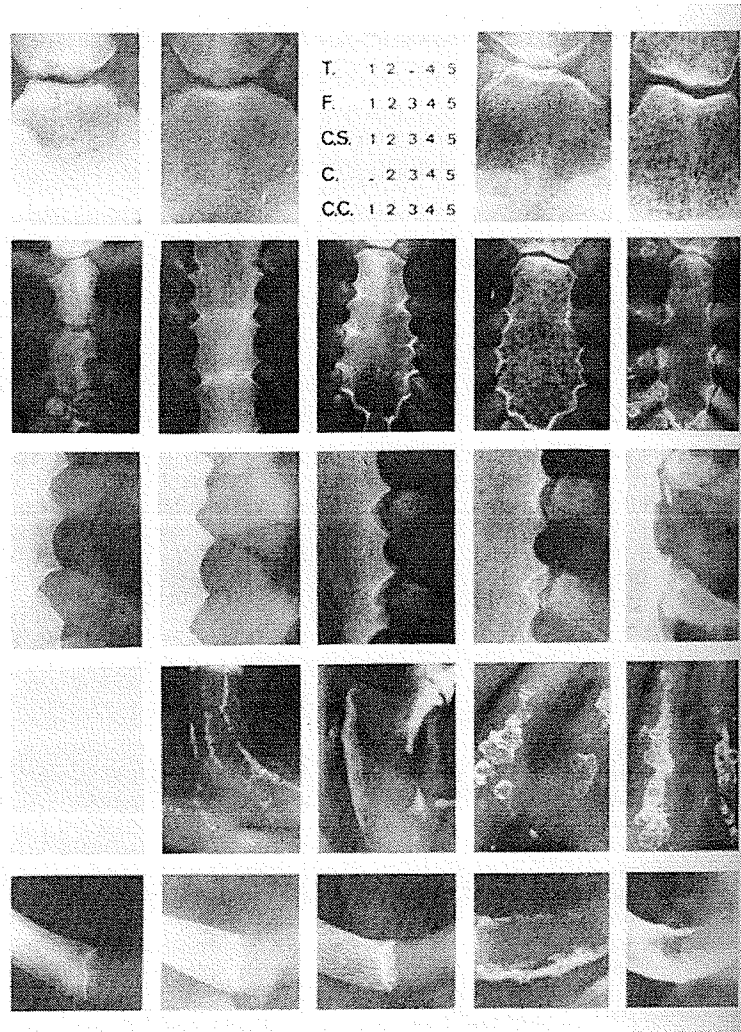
Photographic Template for Feature Assessment of Chest Plate X-Rays
